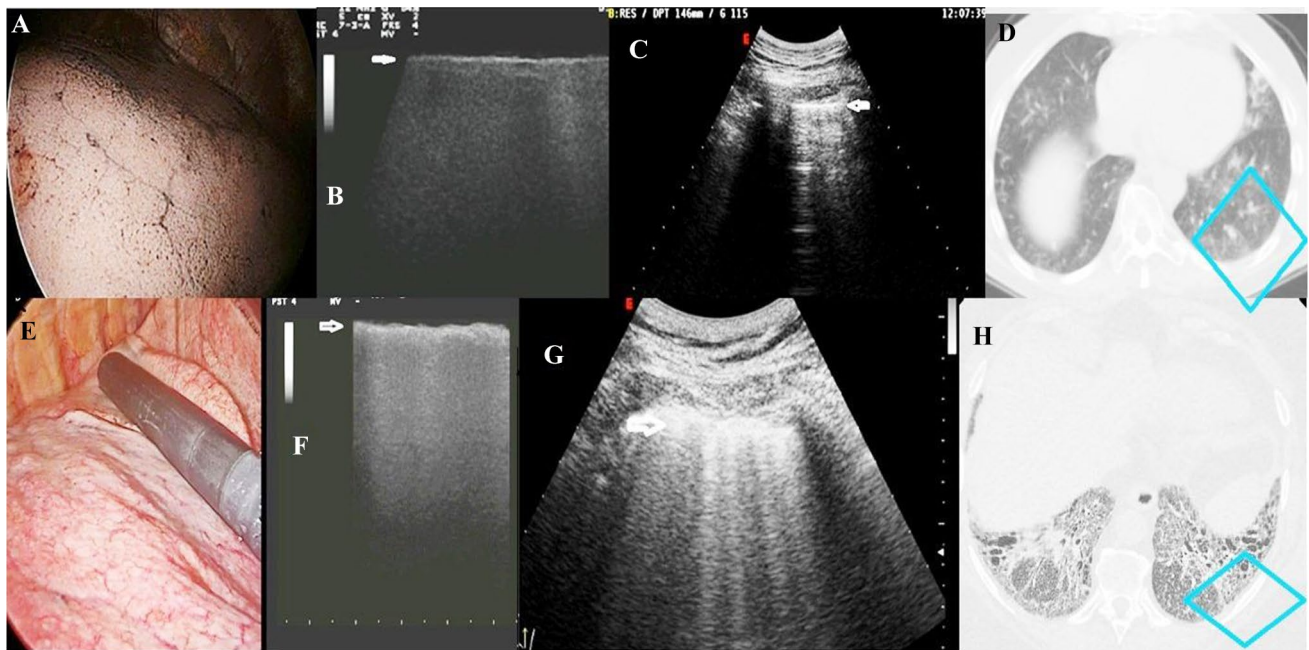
VATS (a), VATS-US (b), TUS (c), and CT (d) images of a tobacco smoker with no fibrosis undergoing resection of pulmonary metastasis from colon adenocarcinoma in comparison with the same images in a patient with a final diagnosis of UIP (e–h). a VATS pattern of patient with no fibrosis; b VATS-US image (linear intraoperative probe, 10 MHz) showing a thin hyperechoic pleural surface (white arrow) in the absence of artifacts; c TUS image (convex probe, 5 MHz) showing a hyperechoic and thin (2.6 mm) pleural line
